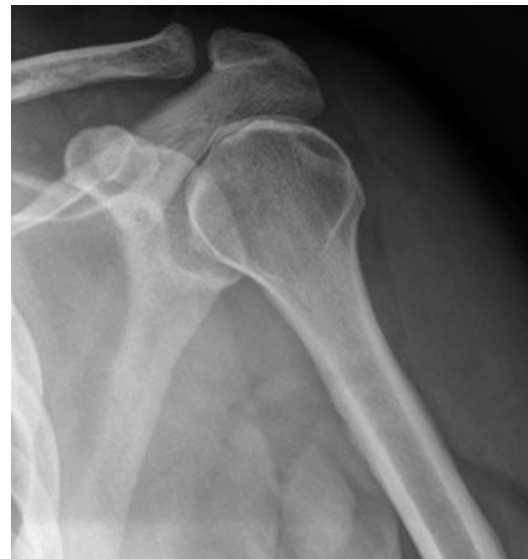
Postreduction anteroposterior radiograph confirms successful reduction of glenohumeral dislocation.
